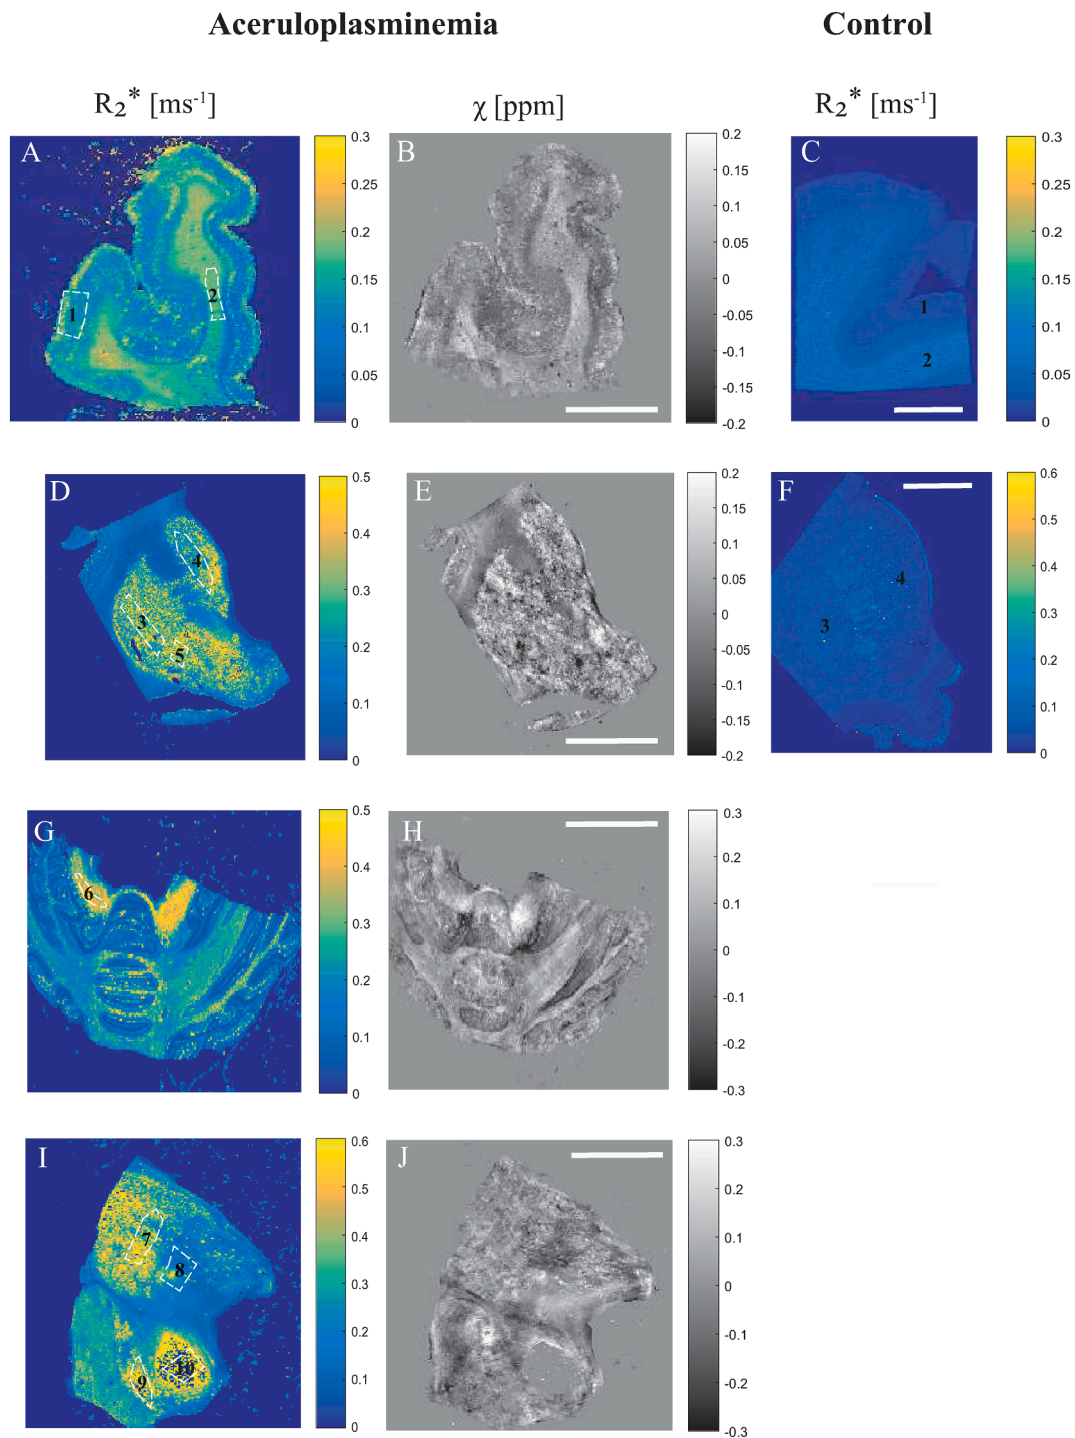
Comparison of quantitative MRI results. The R_2^* and QSM maps are shown with the outlined regions of interest (ROIs) in the temporal cortex (1) and white matter (2) (A, B), putamen (3), caudate nucleus (4) and globus pallidus (5) (D, E), dentate nucleus (6) (G, H), thalamus (7–ateral division, 8–medial division), substantia nigra (9) and red nucleus (10) (I, J) in aceruloplasminemia. Note that for the red nucleus, the susceptibility signal was predominantly masked out (J). R_2^* maps of the temporal cortex (1) and white matter (2) (C), putamen (3) and caudate nucleus (4) (F) of a control subject are provided for comparison. Scalebar, 1 cm. (For interpretation of the references to colour in this figure legend, the reader is referred to the web version of this article.)
